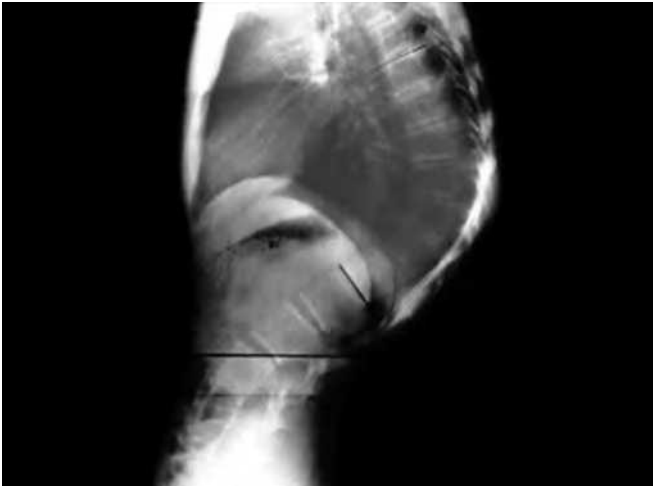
X-ray of a 17-year-old boy showed kyphosis of thoracolumbar segment caused by multilevel vertebral wedging.
